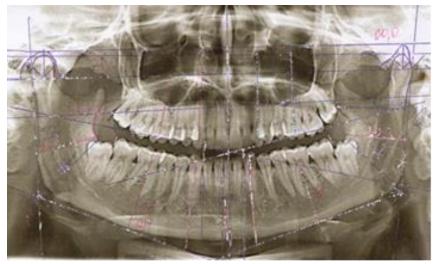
Orthopantomogram of patient M., 22 years. Diagnosis: left-side buccal cross bite.
